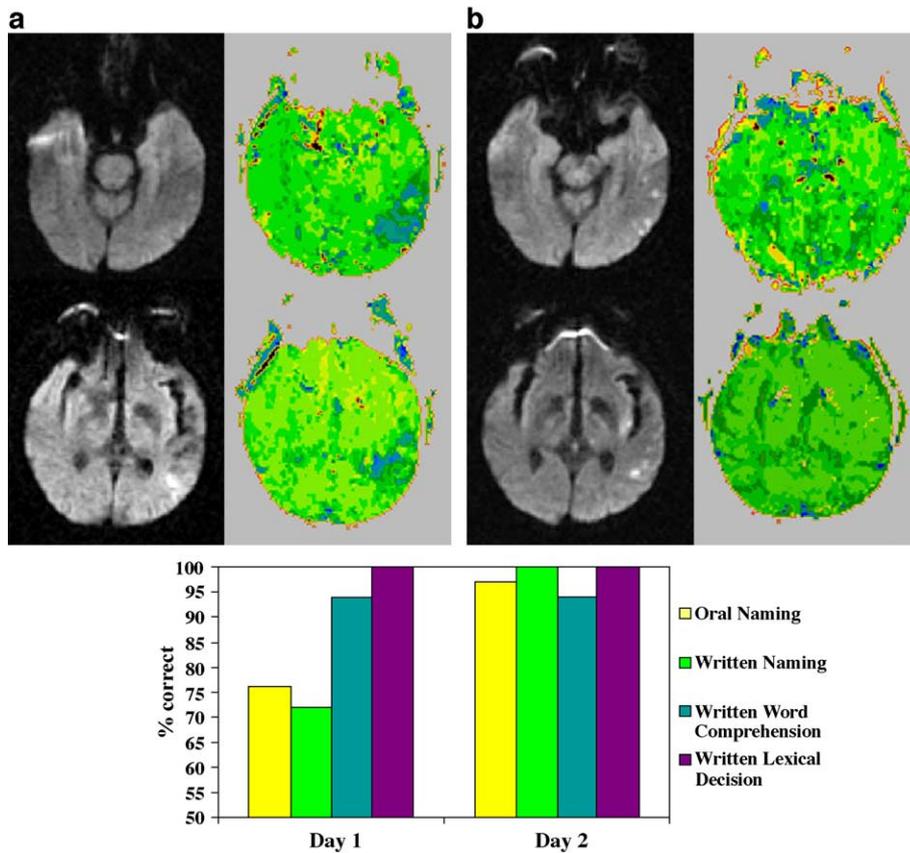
DWI and PWI scans before and after reperfusion of BA 37 (including VWFA). At Day 1, BA 37 was hypoperfused, and oral naming of both pictures and objects to tactile exploration (combined for this graph) and written naming of pictures were impaired. At Day 2, BA 37 was normally perfused, and oral and written naming performance returned to normal.
